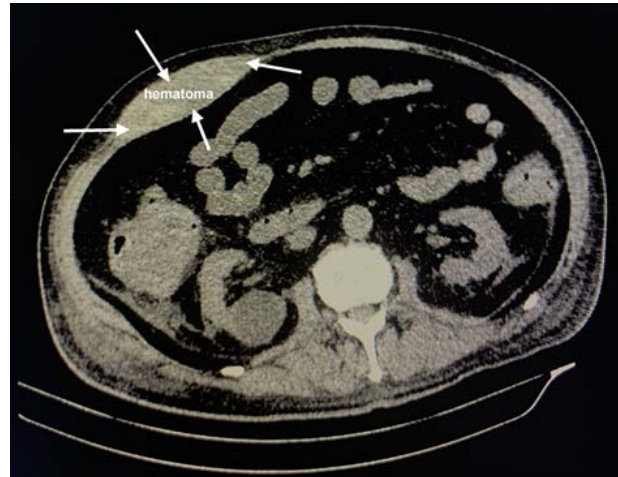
CT-picture (without intravenous contrasting) of hematoma of the right rectus abdominis muscle.
